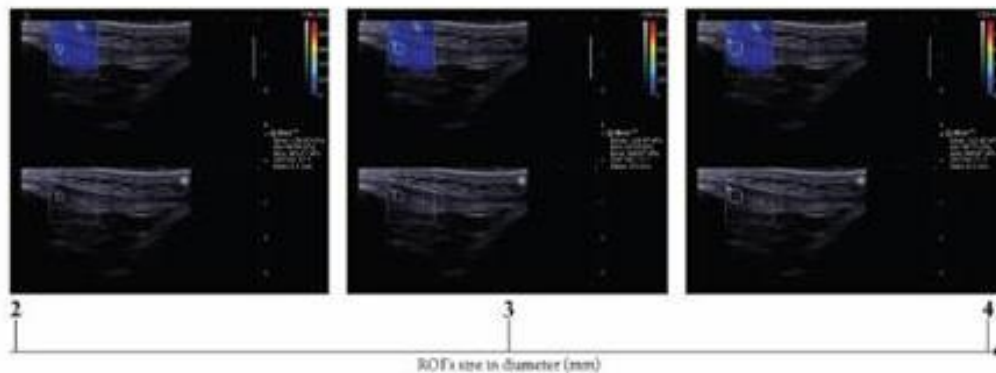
Longitudinal sonograms of patella tendon (PT) with elastic modulus measured by various region of interest (ROI) sizes. Upper images show color-coded box presentations of PT elasticity (stiffer areas were coded in red and softer areas in blue) superimposed on a longitudinal grey scale sonogram of PT, with the circle representing the region of interest and its corresponding elastic modulus demonstrating under Q-Box™ on the right. Bottom images show longitudinal grey scale sonograms of PT on the identical scan planes. Transducer pressure applied was light for 8 to 12 seconds during the acquisition of the SWUE sonogram. doi:10.1371/journal.pone.0044048.g004
